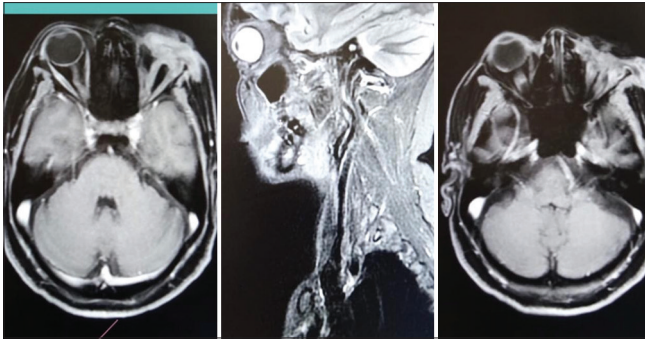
Magnetic resonance imaging revealed mass lesion involving entire left orbital content with no intracranial extension
